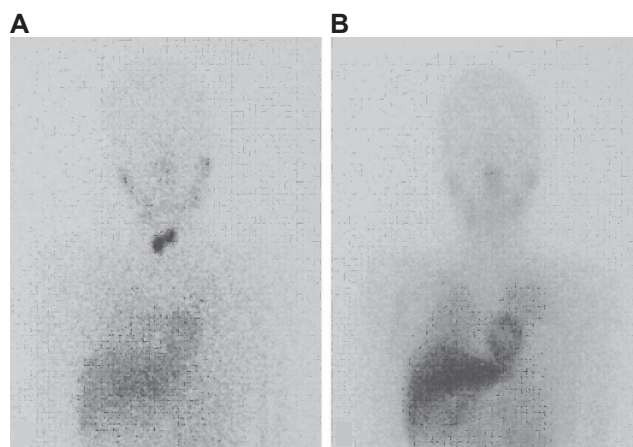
Preoperative and postoperative findings of ^{123}I -MIBG scintigraphy in a 14-year-old female with MEN 2B and recurrent MTC. She had previously undergone total thyroidectomy at 7 years of age, followed by three neck dissections for tumor recurrence. Preoperatively, ^{123}I -MIBG uptake is noted in the central neck region 24 hours after injection of 100 MBq of ^{123}I -MIBG (A). Postoperatively, no increased uptake of ^{123}I -MIBG can be identified at 24 hours after injection (B). Copyright © 2005. Reprinted by permission of Elsevier Inc. from Shimotake T, Tsuda T, Aoi S, et al. Iodine 123 metaiodobenzylguanidine radio-guided navigation surgery for recurrent medullary thyroid carcinoma in a girl with multiple endocrine neoplasia type 2B. *J Pediatr Surg*. 2005; 40(10):1643–1646.
